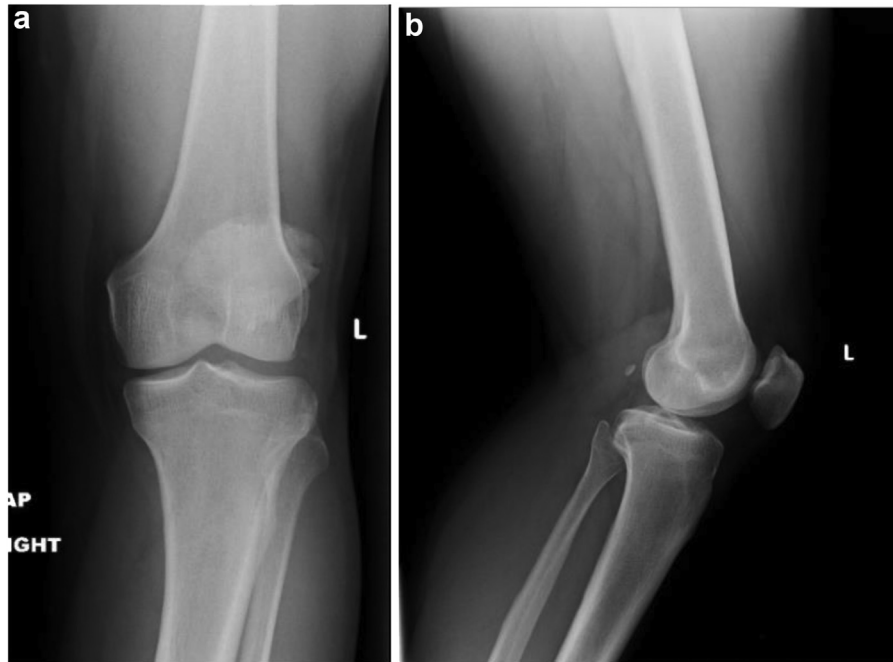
Initial preoperative anteroposterior (a) and lateral (b) weightbearing radiographs of the left knee.
